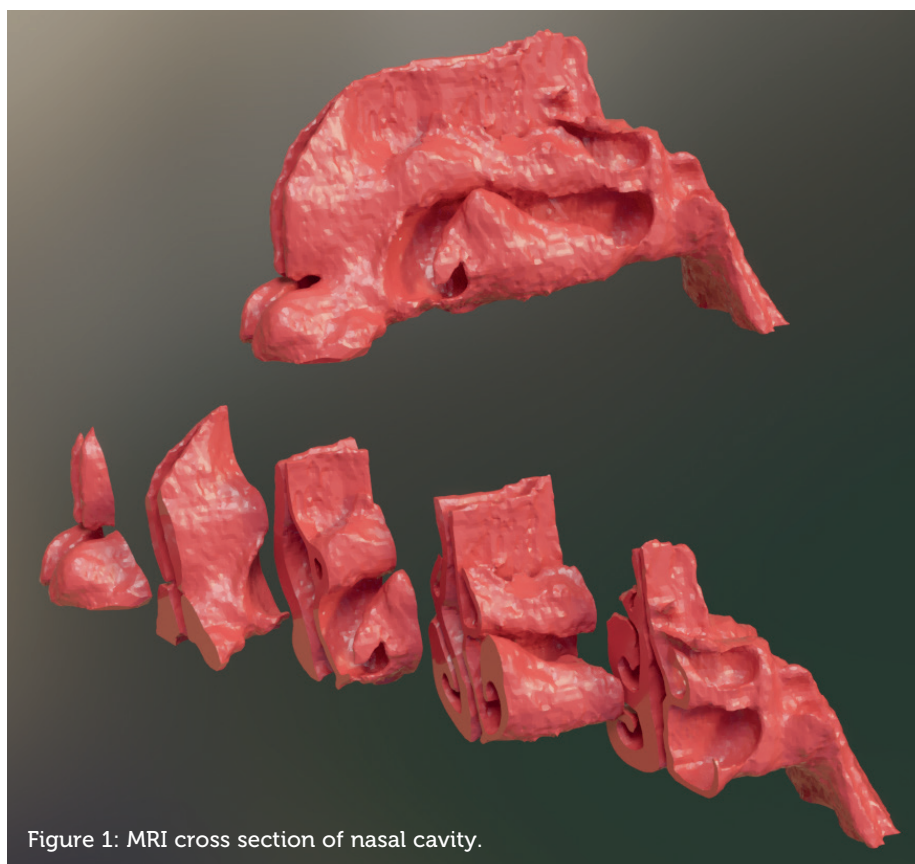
MRI cross section of nasal cavity.
